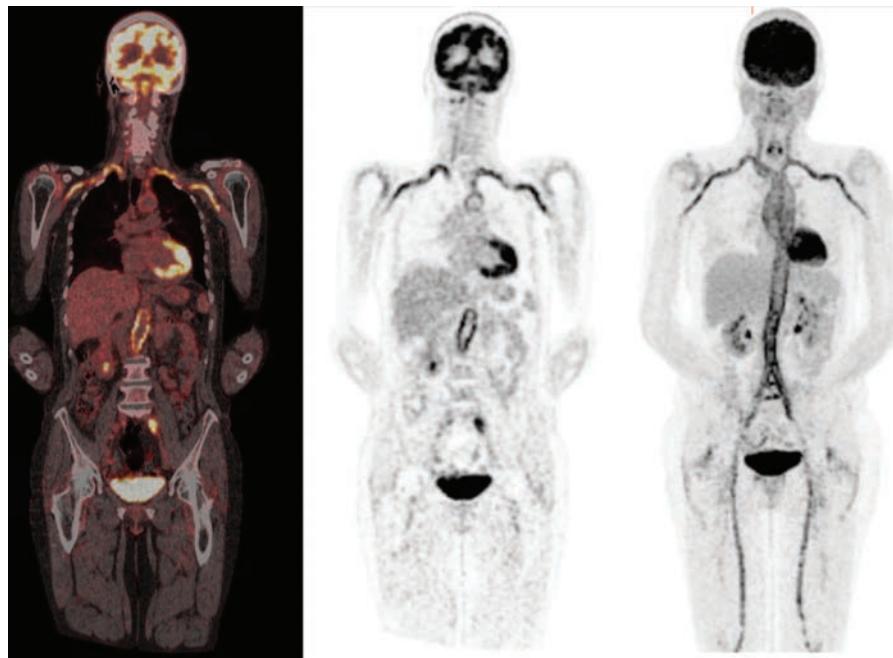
FDG-PET/CT in a patient with FUO. This 72-year-old woman presented with a low-grade fever and severe fatigue of almost 3 months' duration. An extensive history was taken, but the patient had no specific complaints and had not traveled recently. Her previous history was unremarkable, and she did not use any drugs. Physical examination, including palpation of the temporal arteries, yielded completely normal results. Laboratory examination showed normocytic anemia, a C-reactive protein level of 43 mg/L, an erythrocyte sedimentation rate of 87 mm/h, and mild hypoalbuminemia. Results of the other obligatory tests were all normal. Since there were no potentially diagnostic clues, FDG-PET/CT was performed. This test showed increased FDG uptake in all major arteries (carotid, jugular, and subclavian arteries; thoracic and abdominal aorta; iliac, femoral, and popliteal arteries) and in the soft tissue around the shoulders, hips, and knees—findings compatible with large-vessel vasculitis and polymyalgia rheumatica. Within 1 week after the initiation of treatment with prednisone (60 mg once daily), the patient completely recovered. After 1 month, the prednisone dose was slowly tapered.
